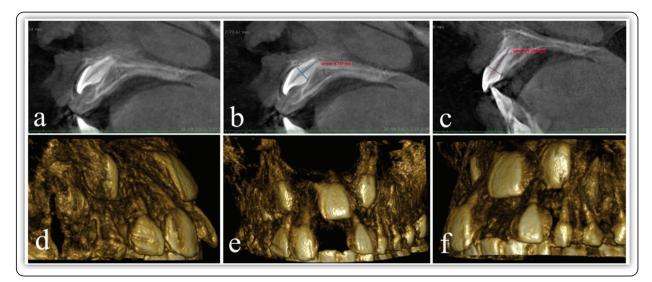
Different CBCT views of the unerupted LMCI. (a) sagittal view shows the LMCI with an open apex and the impaction in the labial side. (b) shows the length of the LMCI root to be about 8.2 mm, shorter by about 4 mm when compared to the root of the RMCI (c). (d, e, and f) are different three- dimensional views showing the positional relationship of the LMCI to the neighboring teeth.
